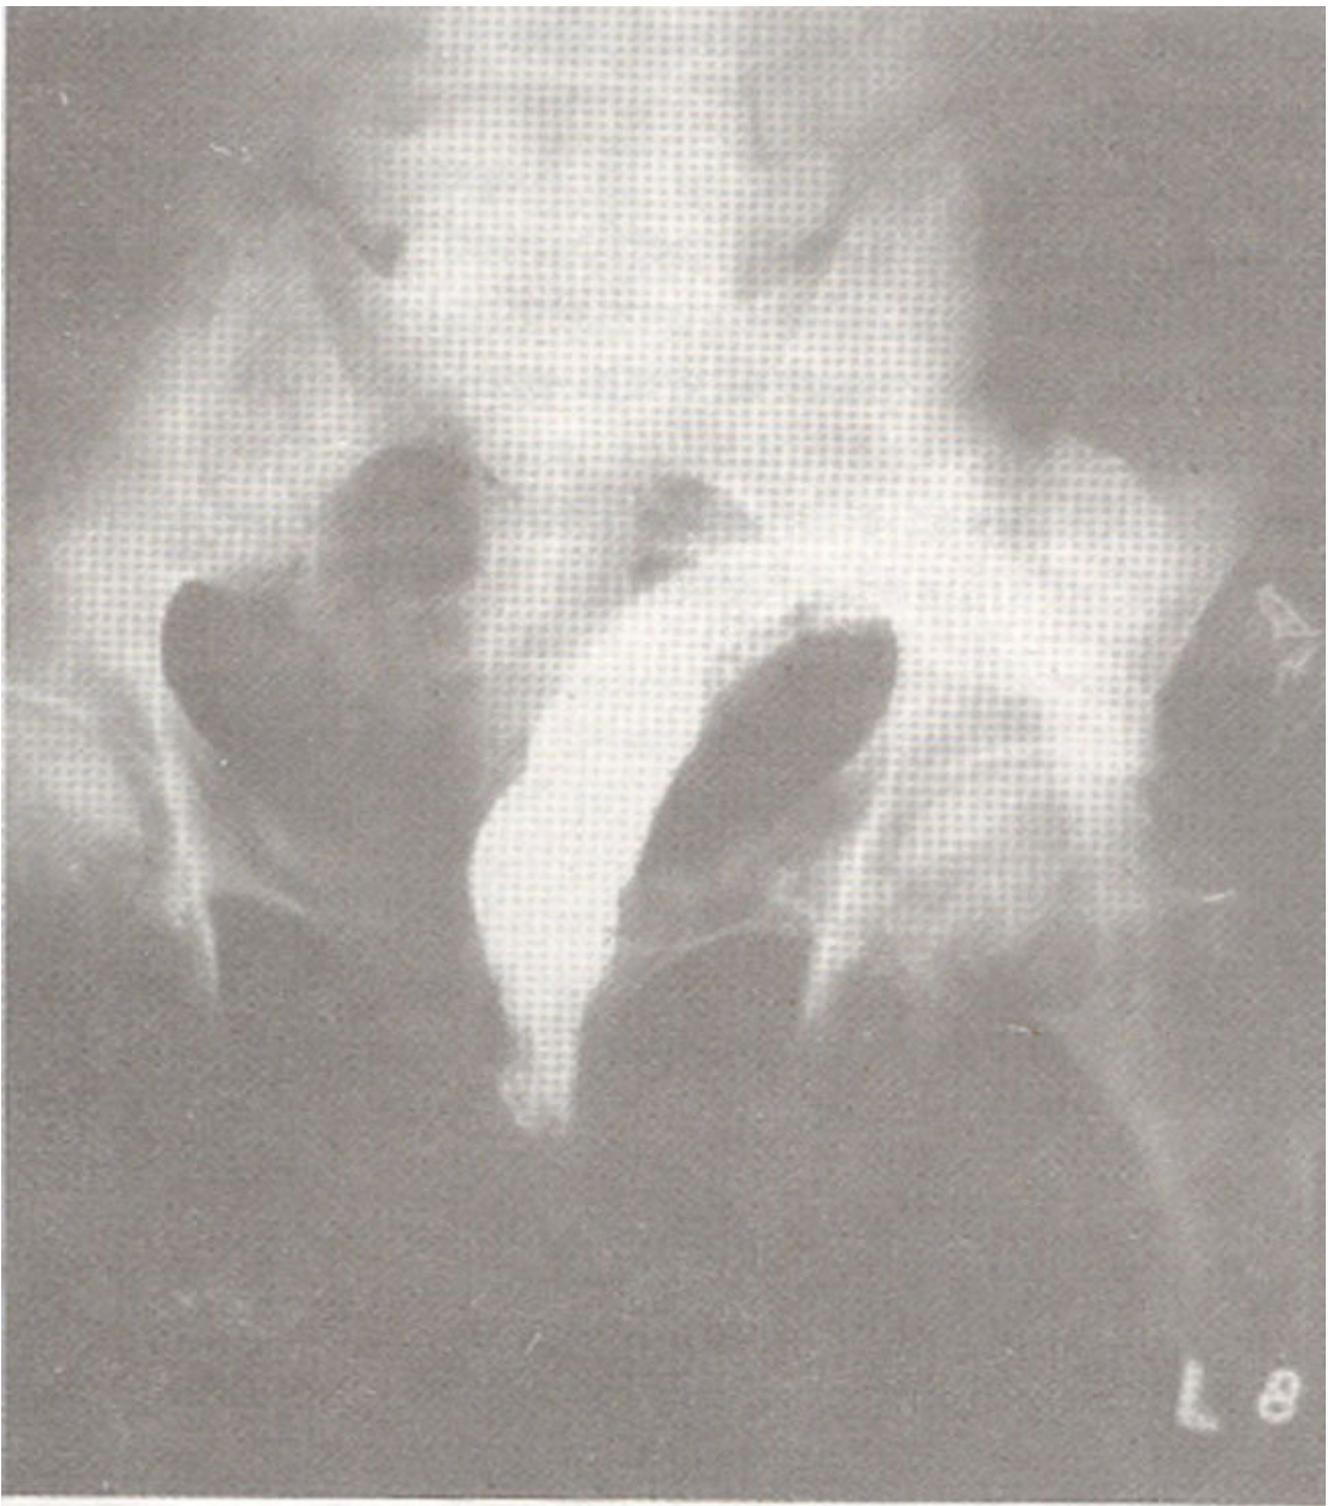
X-ray after the splint.
